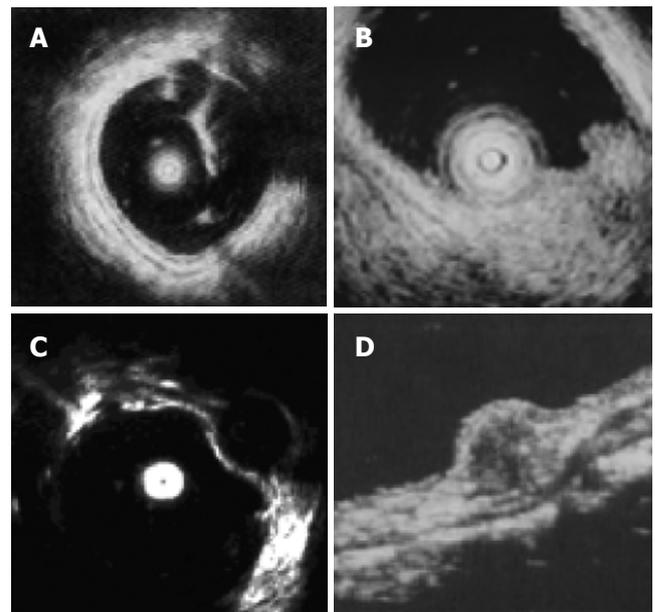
Endoscopic ultrasonography images of normal wall and submucosal tumors of the large intestine are presented. A: The normal wall displayed in 5 layers; B: Lipoma image showing a hyperechoic homogeneous mass located in the third layer; C: Leiomyoma image showing a hypoechoic homogeneous mass originated from the 4th layer; D: Rectal carcinoid image showing a submucosal hypoechoic mass with a homogenous echo. Courtesy by PH Zhou (Zhou, 2004 128 /id).
